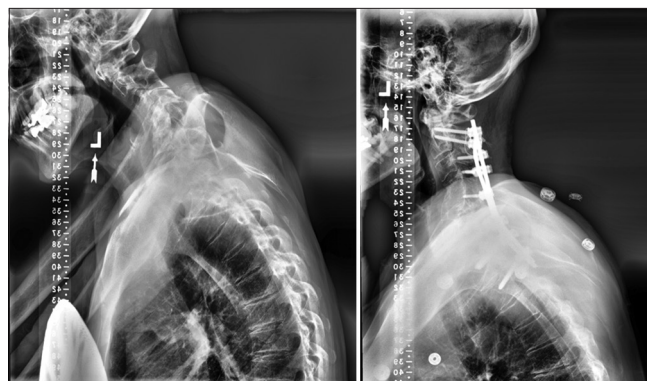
Neutral standing radiographs, preoperative (left) to 1Y postoperative (right) changes in a patient with baseline hyperkyphosis (baseline: C2–C7 Cobb angle = -34.4°). Cervical lordosis was significantly restored at 1Y (C2–C7 Cobb = 4.3°) and cervical sagittal vertical axis significantly reduced (39.24 to 25.37 mm) without need for revision
